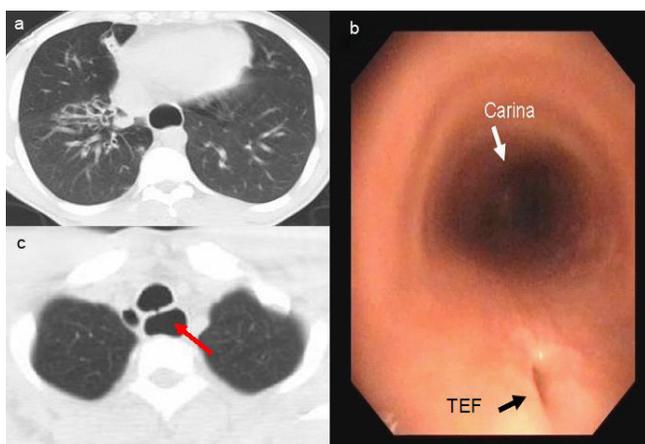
a. Thorax computed tomography section showing bronchiectasis at the middle and lower lobes of the lung. b. Bronchoscopic view of the orifice at the posterior wall of trachea, considered a TEF. c. Computed tomography section supporting our consideration of TEF.
